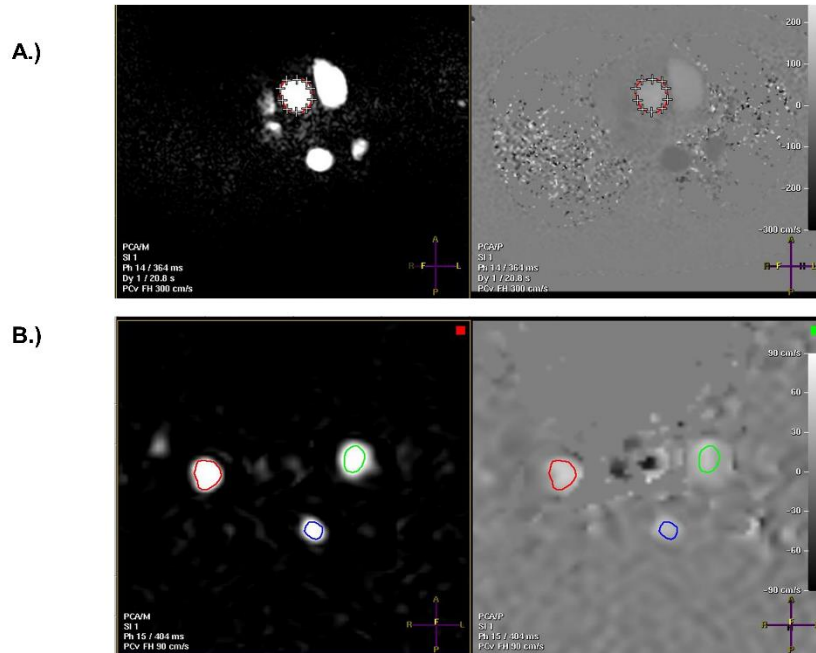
Example PC-MRI analyses in Philips View forum. A.) AO flow analyses and B.) 2D Q_{flow} analyses. ROI's drawn around target vessel (ascending aorta for AO flow and internal carotid arteries and basilar for 2D Q_{flow}) on magnitude image shown on the left. Corresponding phase image shown on the right, where ROI can be adjusted.
